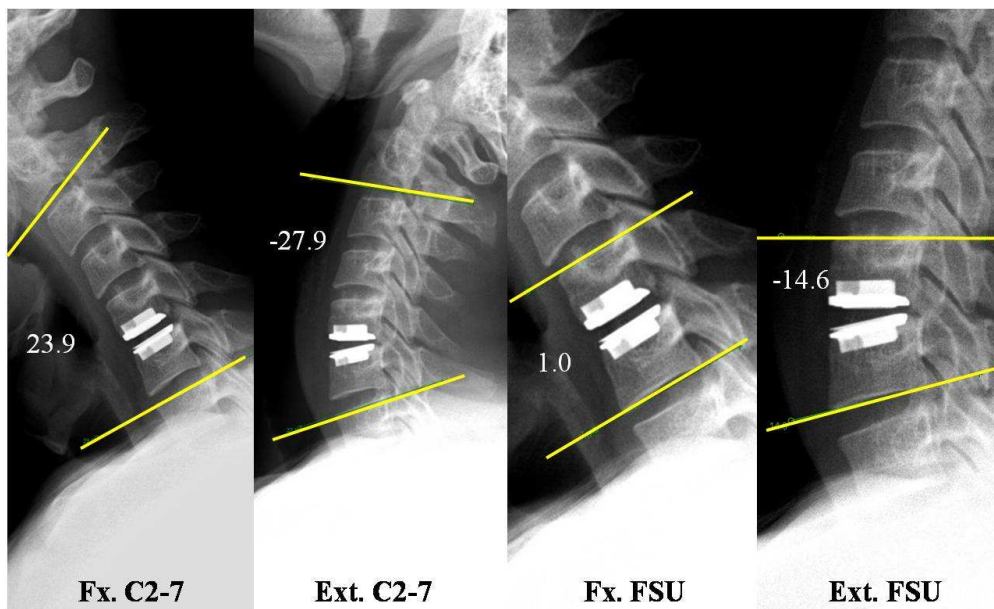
Cervical flexion–extension lateral X-ray films after a C5–6 ProDisc-C replacement. The range of motion (ROM) of the cervical spine was defined as the difference between the Cobb's angles of the flexion and extension lateral radiographs at the C2–7 segments (Fx. C2–7 and Ext. C2–7) and the C5–6 functional spinal unit (Fx. FSU and Ext. FSU). Fx., flexion; Ext., extension; FSU, functional spinal unit.
